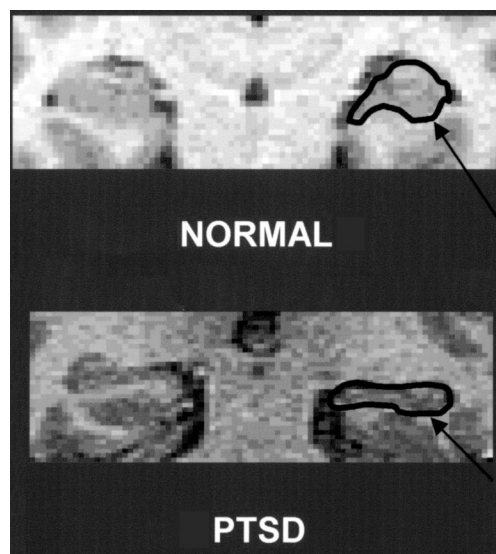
Hippocampal volume in abuse-related PTSD. Hippocampus is shown on a coronal magnetic resonance imaging (MRI) scan in a representative patient with abuse-related PTSD and a normal control. There is a visible reduction in the hippocampus (outlined) in a patient with abuse-related PTSD relative to a normal subject.
